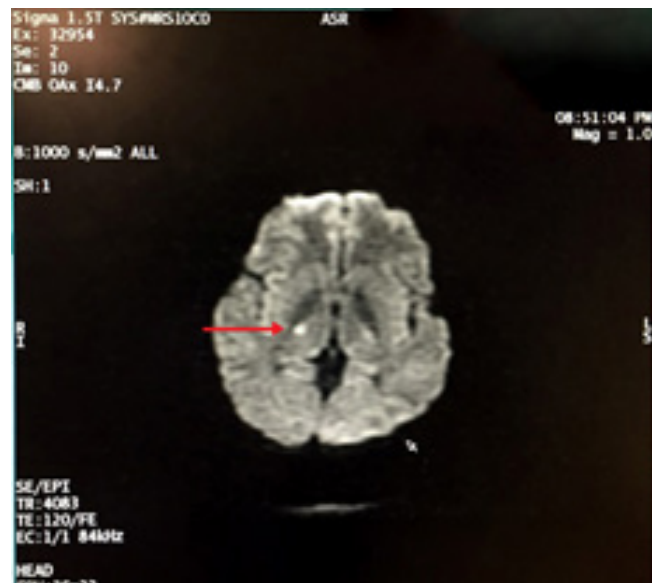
Plain Brain MRI (DWI) of patient case with Acute Right Thalamic Infarct (red arrow)
